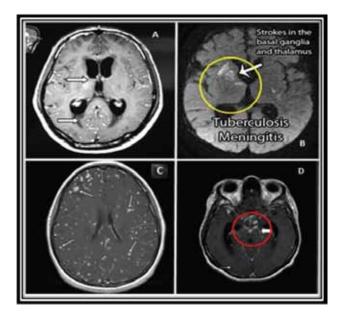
MRI Brain in CNS TB
